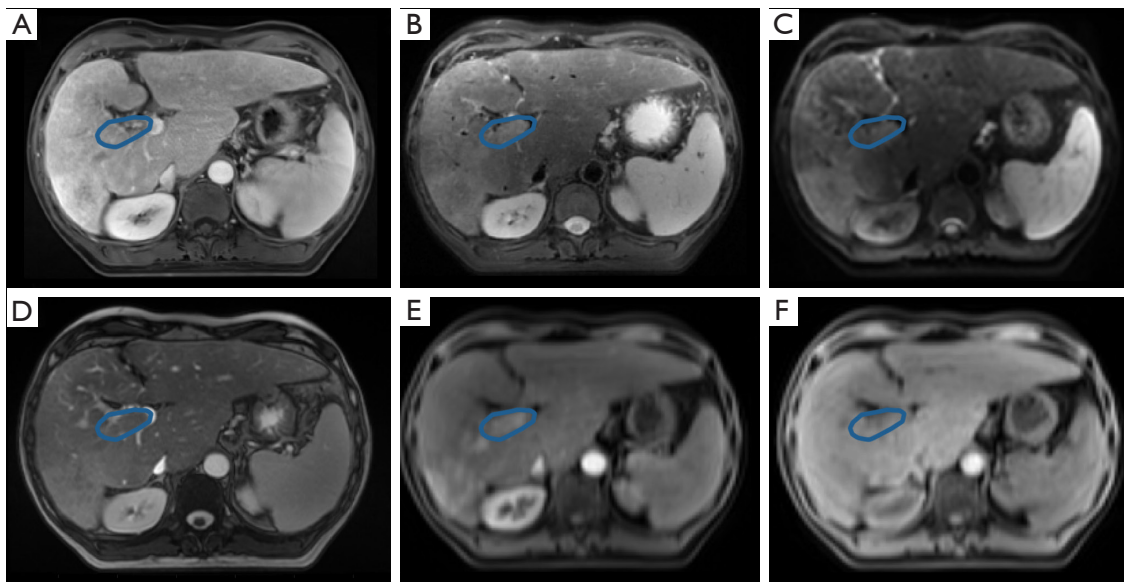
MRI images of an example patient. (A) T1W MRI. (B) T2W MRI. (C) DWI with $b=800 \text{ s/mm}^2$. (D) Axial 2D Cine MRI. (E) 4D-MRI_{CE}. (F) 4D-MRI_{NC}. The blue outline indicates the position of the lesion. 4D-MRI, four-dimensional magnetic resonance imaging; 4D-MRI_{CE}, contrast-enhanced 4D-MRI; 4D-MRI_{NC}, non-contrast 4D-MRI; DWI, diffusion-weighted imaging; T1W, T1-weighted; T2W, T2-weighted.
